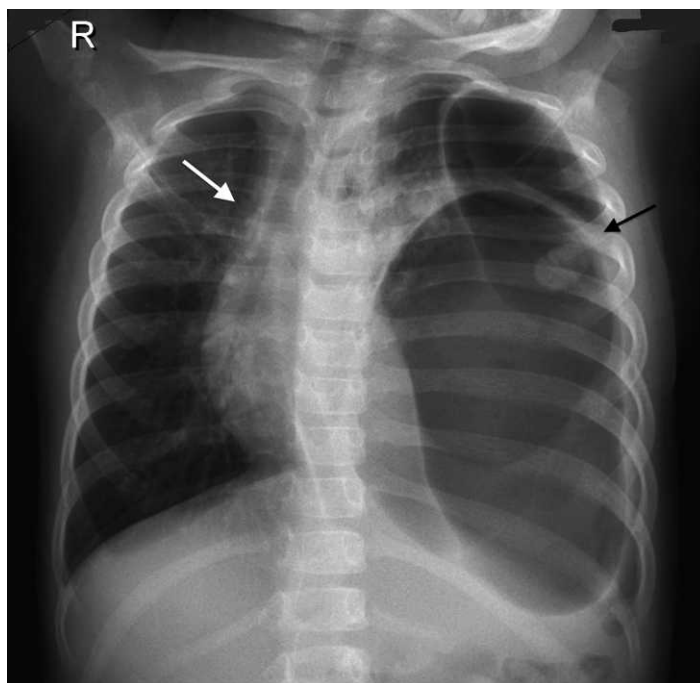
Chest radiograph of a 4-year-old-girl who presented with abdominal pain after minor trauma, showing a large, gas-filled structure in the left hemithorax (black arrow) and mediastinal shift (white arrow) and poor definition of the left diaphragm.
